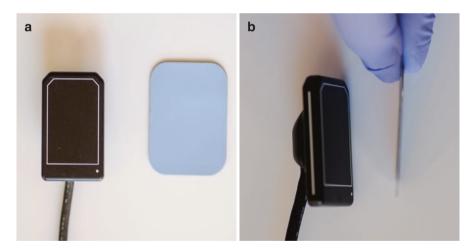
Digital image sensors for intraoral radiography—rigid sensor with a wire and a photostimulable storage phosphor plate (a) tube side and (b) lateral aspect
